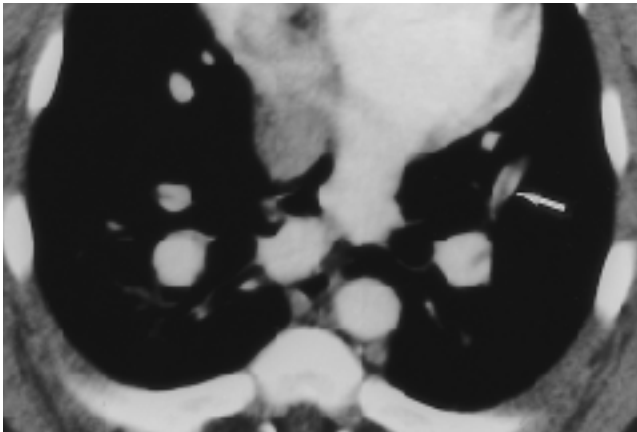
Emboli in the transversely oriented vessels. Contrast-enhanced spiral CT scan obtained after induction of pulmonary embolism demonstrate filling defect in transversely oriented vessel (arrow) .
